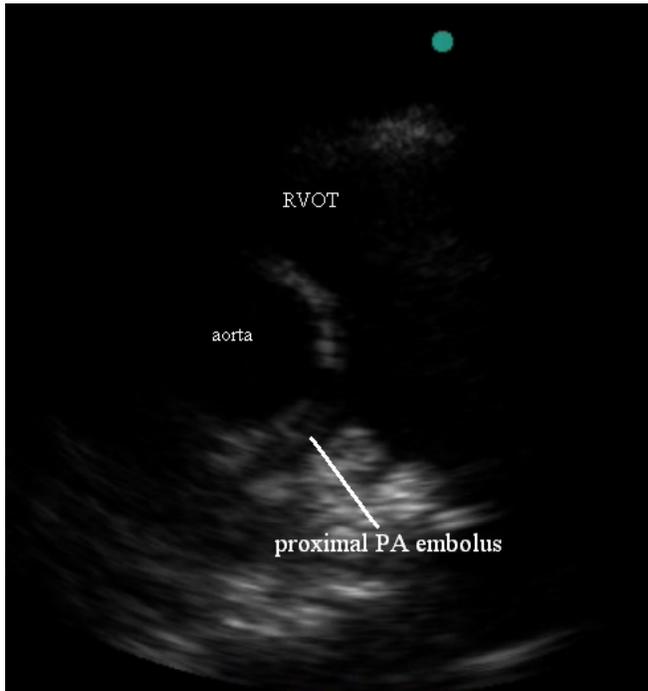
Modified parasternal short view allowing the visualization of proximal pulmonary arteries; RVOT= RV outflow tract.
